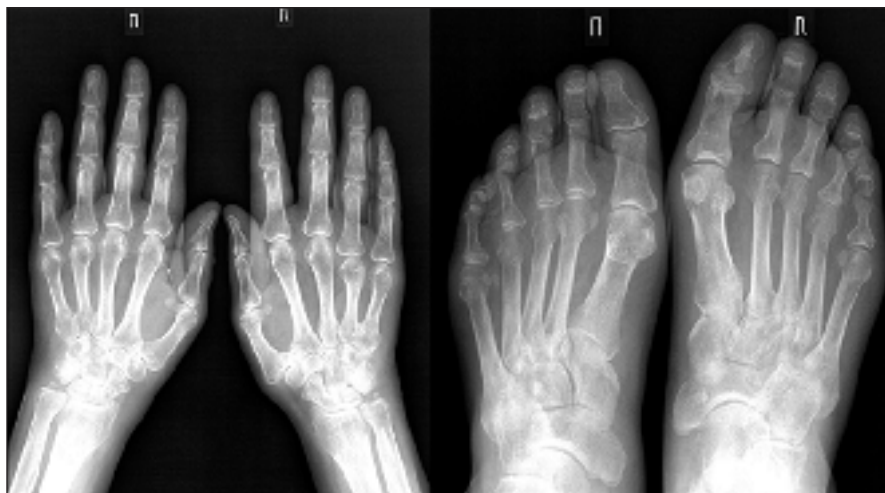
X-ray of the hands and feet of patient N.
